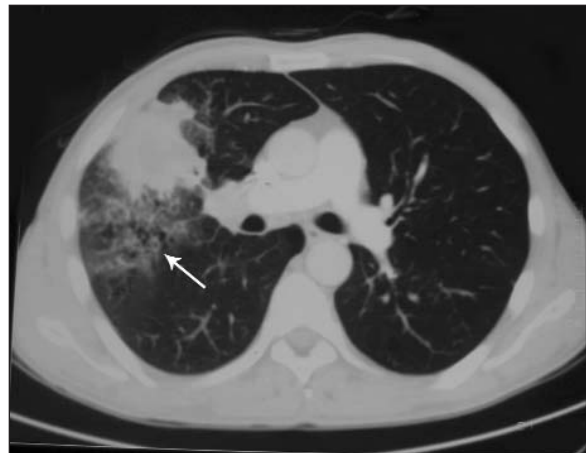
The follow-up CT scan showing the expansion of the consolidated area in the right lung.
